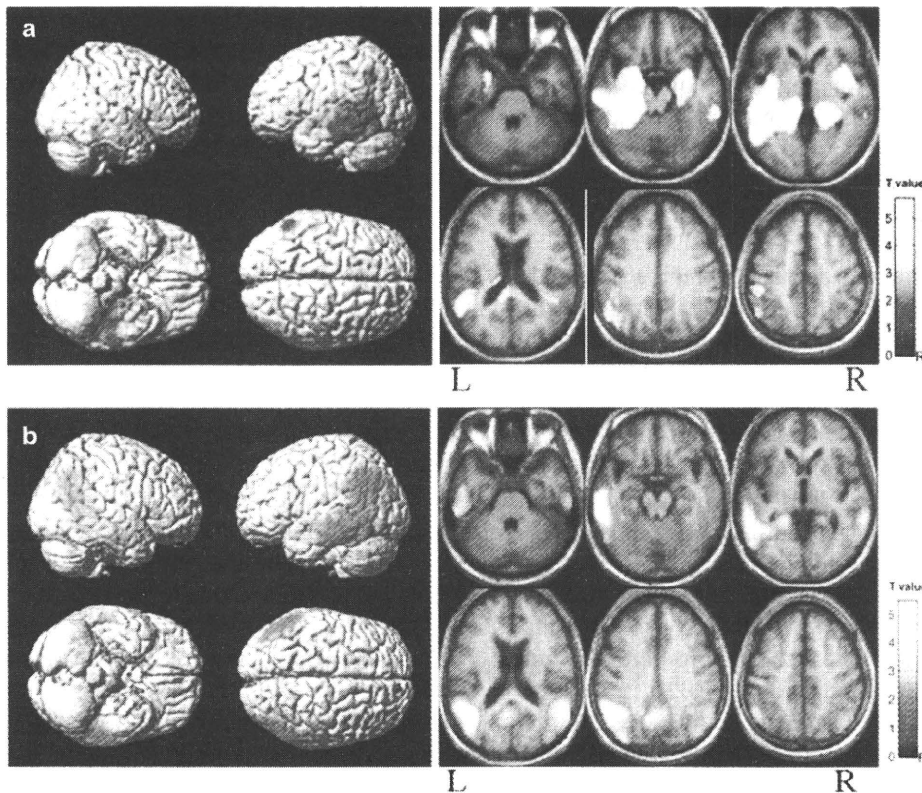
Statistical analyses of the binding potential of [^{11}C]MPDX (a) and standardized uptake value (SUV) of [^{18}F]fluorodeoxyglucose (FDG, b) in patients with Alzheimer's disease. *Left* Statistical parametric mapping (SPM) Z maps are superimposed onto the right lateral, left lateral, inferior, and superior views (from *left upper* to *right lower*) of a volume-rendered spatially normalized magnetic resonance imaging (MRI) study. *Right* SPM Z maps are superimposed onto the axial views of a spatially normalized T1-MRI study. Each image represents from the *bottom (left upper)* to
